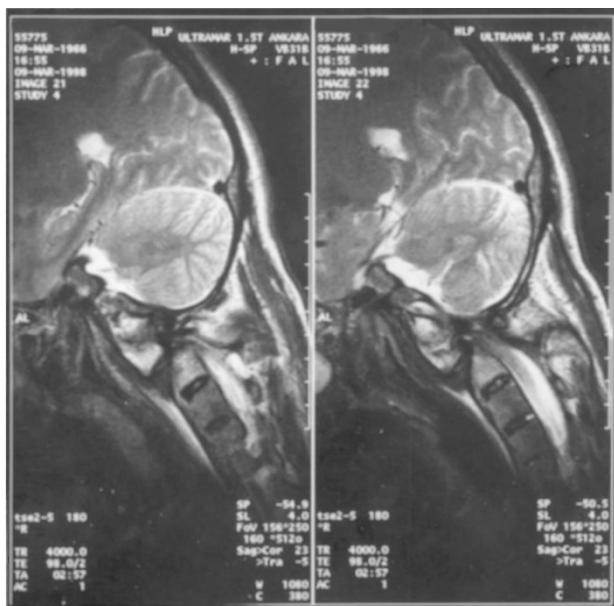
T2-weighted sagittal MRI of the cervical spine shows odontoid fracture, anterior sliding of atlas, and cord compression
